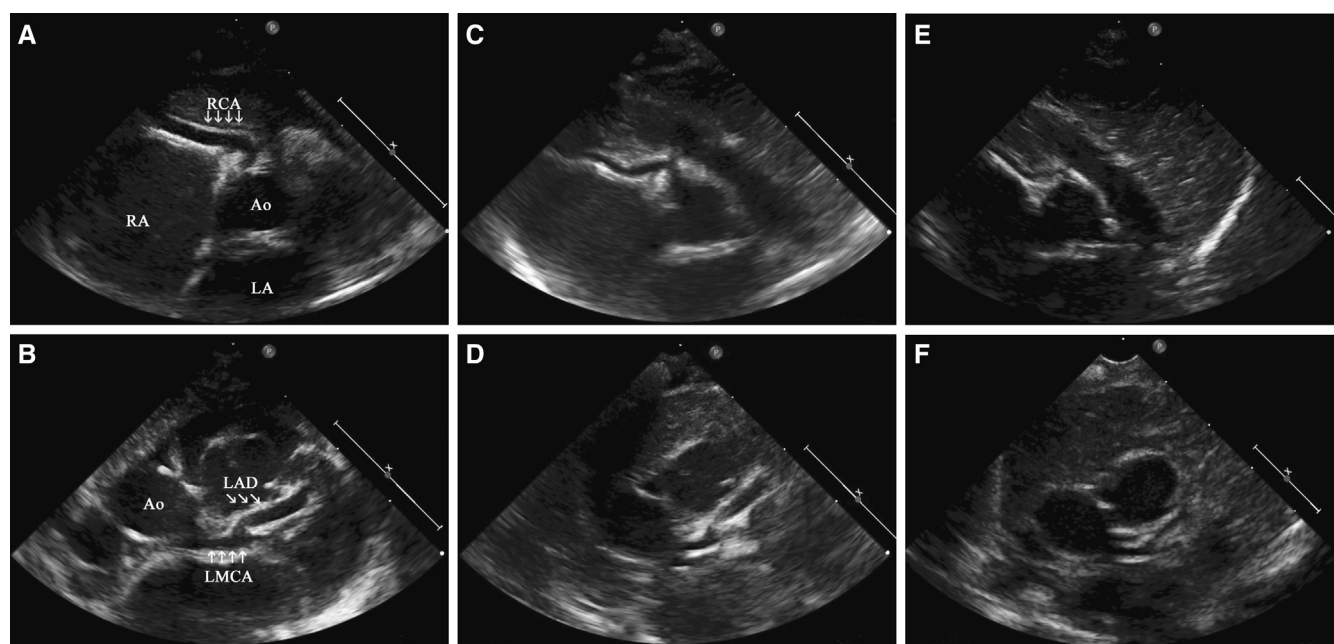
Parasternal short-axis echocardiogram view on admission showing uniform dilation of A, RCA and B, LMCA and LAD. Same view after first IVIg course and on systemic steroids, demonstrating initial positive remodeling of coronary arteries, more evident in C, RCA and D, LMCA. Parasternal short-axis echocardiogram view on discharge documenting complete resolution of coronary artery dilation, with E, normal RCA and F, LMCA and LAD cross-sectional diameters. Ao, aorta; LA, left atrium; RA, right atrium.
